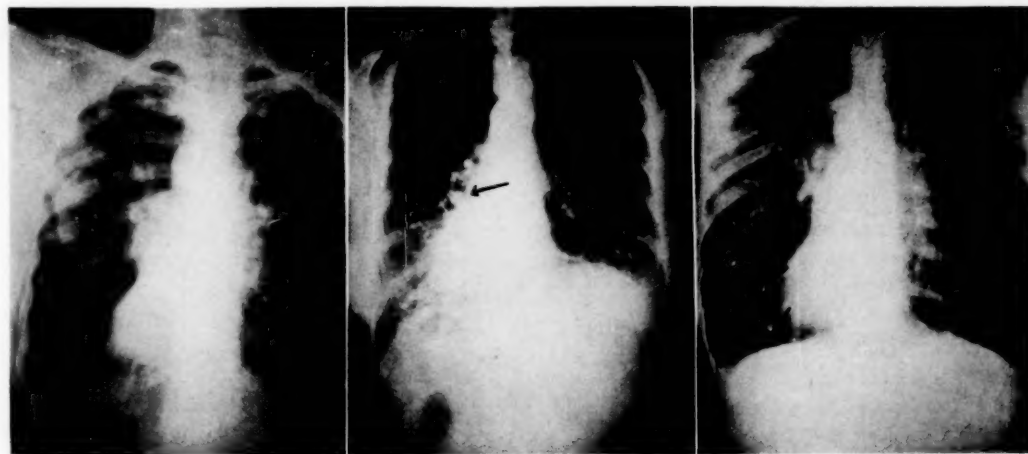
Roentgenogram of chest in whom a clinical diagnosis of bronchiectasis was made. Unable to detect cavities.
